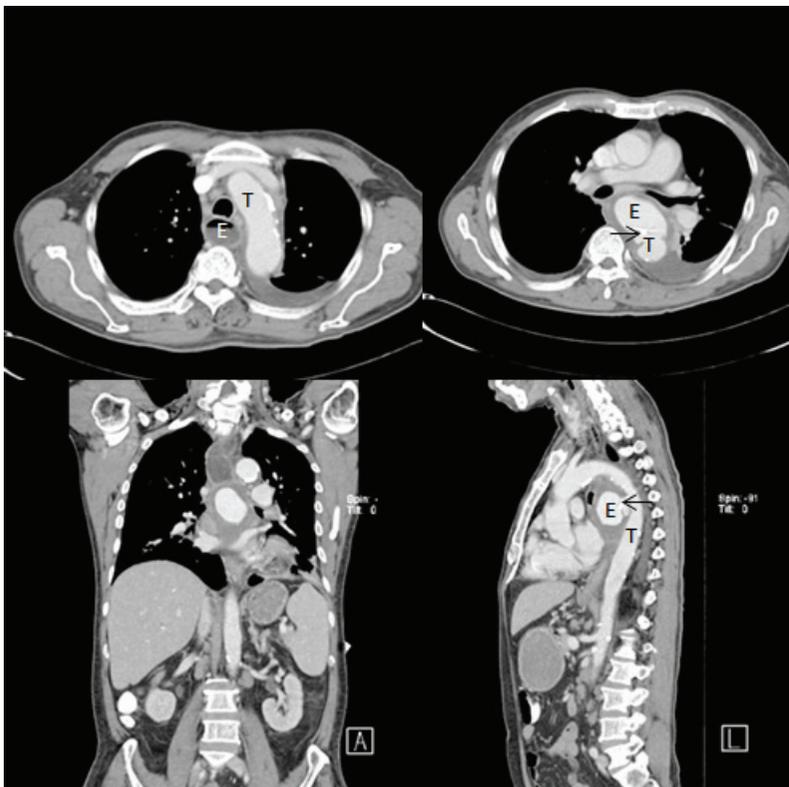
CT scans of a thoracic aortic aneurysm showing an aorto-esophageal fistula with contrast leakage to the esophagus. The arrow identifies an aorto-esophageal fistula. E: esophagus, T: thoracic aorta.
